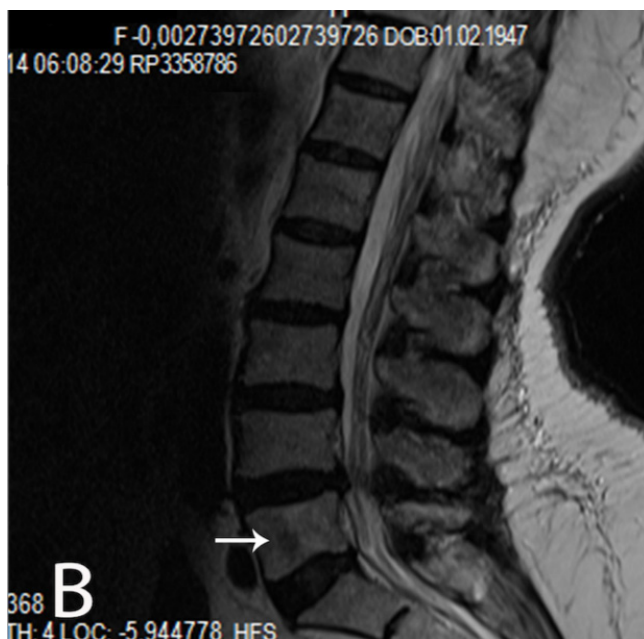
Lumbar MRI showing focal lesion with suspected metastasis.
